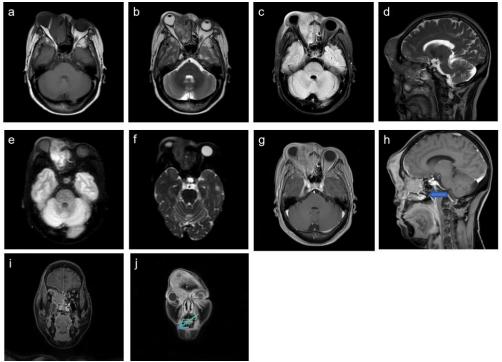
The mass on the sinus MRI TWI showed equal and low signal; b,d) T2W in axial and sagittal positions is a mixed slightly higher signal; c)T2W_FLAIR is obviously high signal; e)DWI is a high signal, f) ADC is a low signal; g~j) enhancement showed uneven and obvious enhancement. The mass invaded the right prefrontal cortex across the frontal bone, and the right frontal bone was destroyed and thinned (); The skin of the right eyelid was thickened, and thickened and strengthened().
